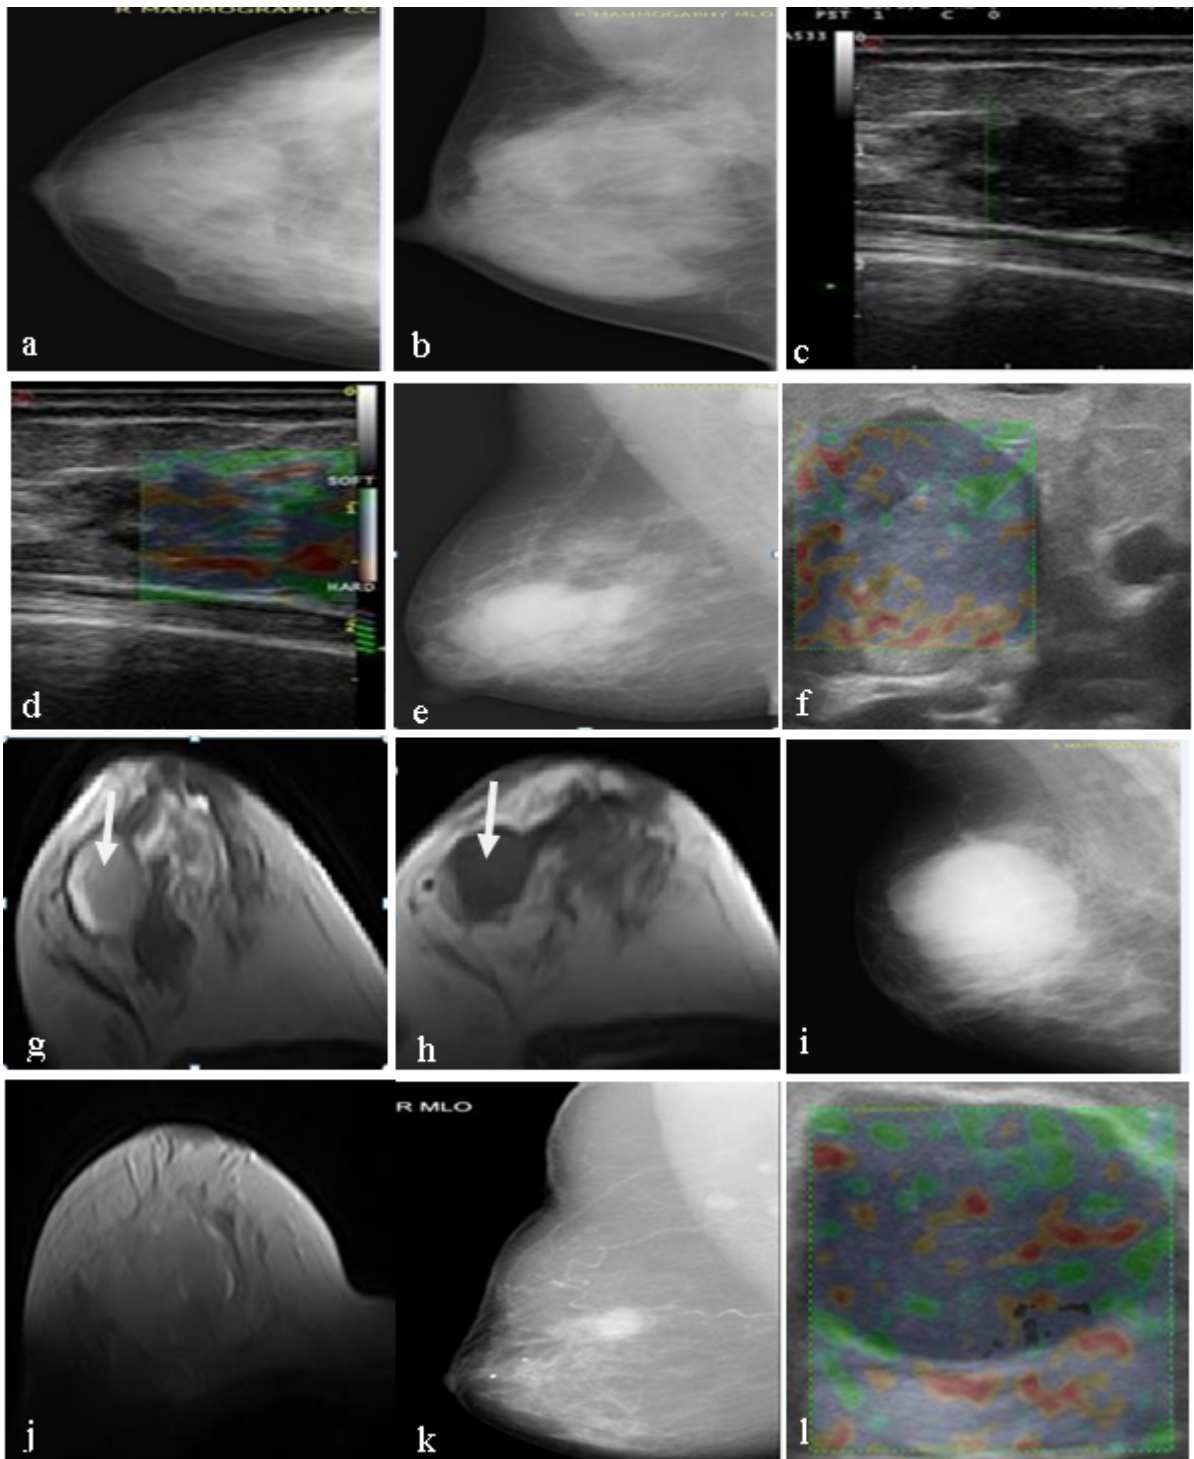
a. Sclerosing adenosis-RT CC, b. Sclerosing adenosis -RT MLO, c. Sclerosing adenosis-B Mode US, d. Sclerosing adenosis-RT MLO, e. Papillary carcinoma-RT MLO, f. Papillary carcinoma-UE, g. Papillary carcinoma-T2W MRI , h. Papillary carcinoma--T1W MRI . i. Intraductal carcinoma –RT MLO, j. Intraductal carcinoma-T2W MRI. k. Medullary carcinoma –RT MLO, l. medullary carcinoma - B mode US.
